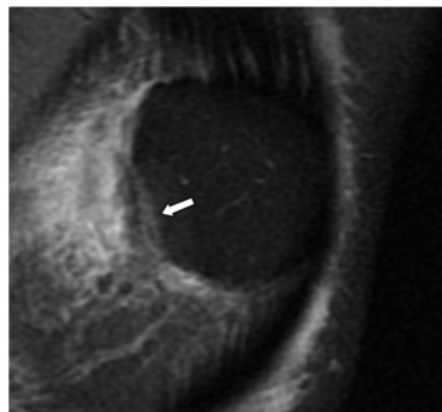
Osteochondral defects of the inferomedial patellar border on T2-weighted fat-saturated MR images.
